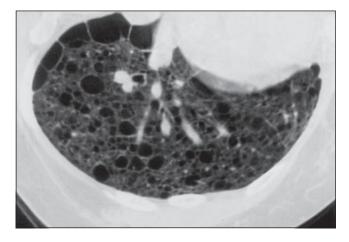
LAM. CT scan from the patient in Fig 13 demonstrating multiple thin-walled cystic radiolucencies throughout lung parenchyma consistent with LAM. Note that both the central and peripheral regions of the lungs are involved.
